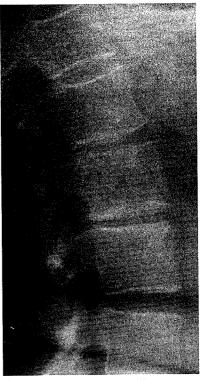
Plain radiograph: expansion and heterogeneity of the body of L2.
